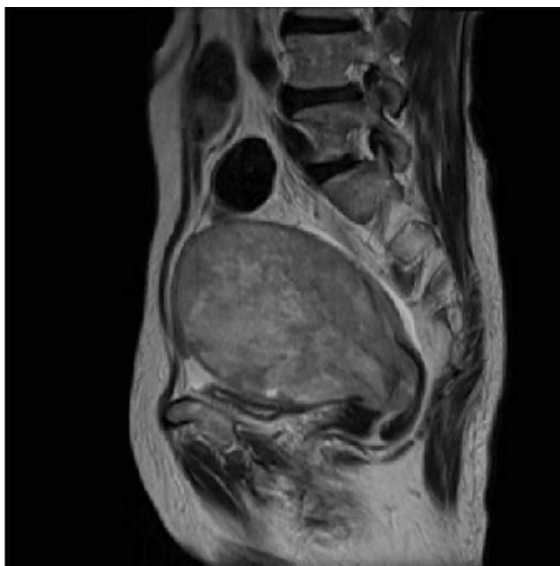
MR imaging showing a large mass of mixed signal intensity in the entire uterine wall.
